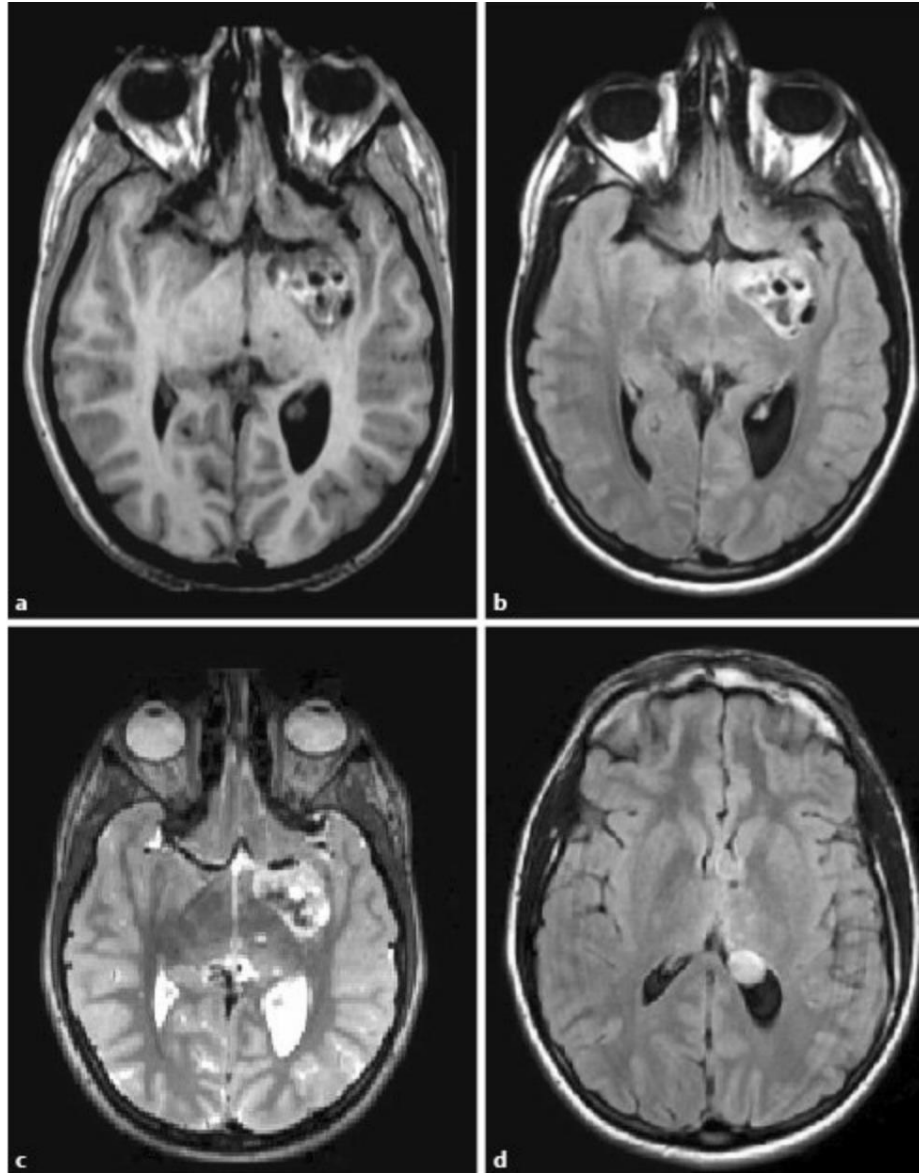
Radiographic images of intracranial mass.
